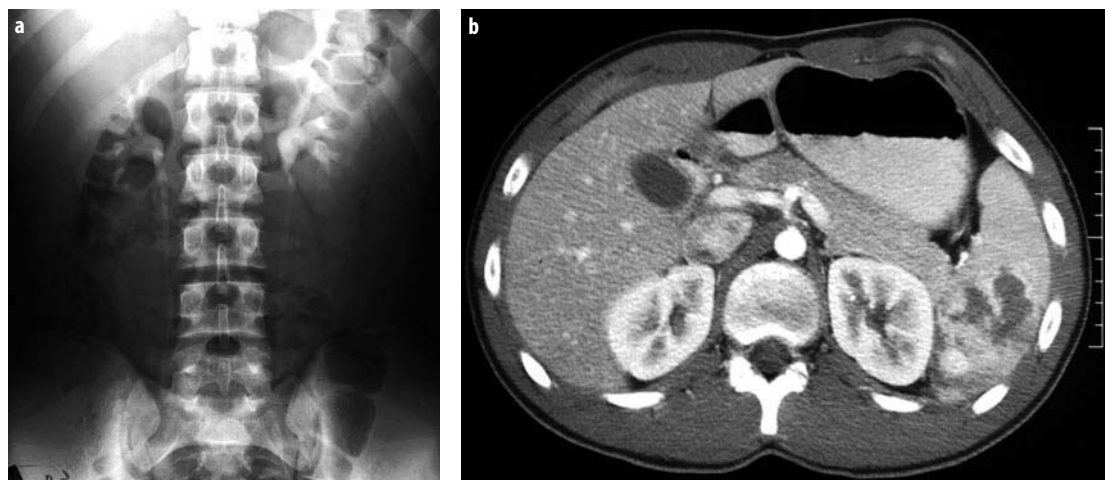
a, b. Hematuria and left upper quadrant pain after a football-related injury. a Intravenous urogram shows no abnormality. b Subsequent CT for persistent pain showed free fluid in the pelvis and extensive splenic laceration with extensive "blush". Surgery confirmed a grade 4 splenic injury
